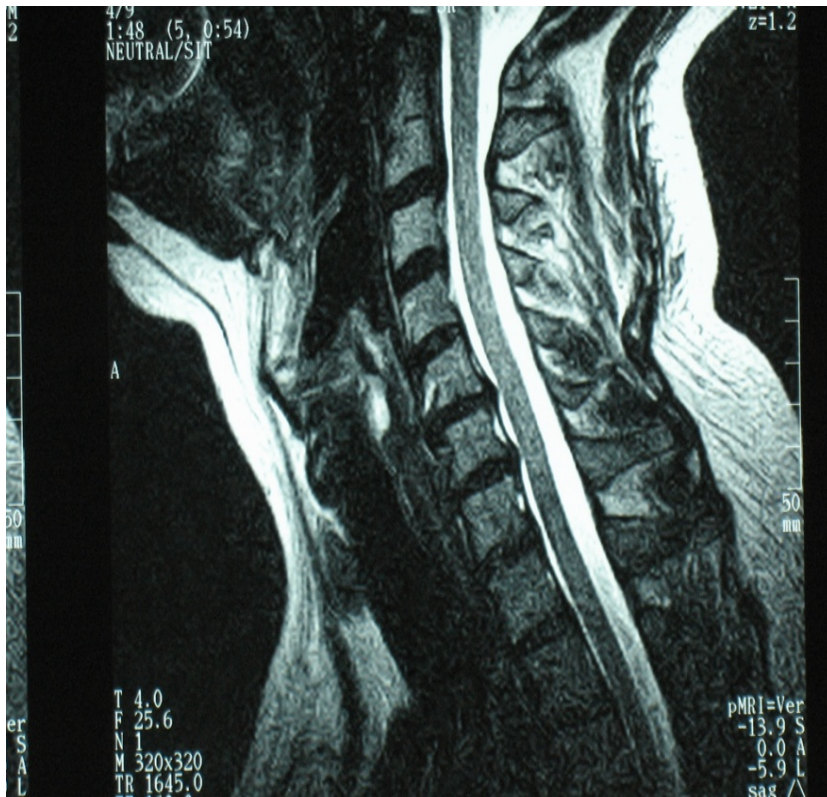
Cervical spine MRI, sagittal view. Note possible extruded disc material at C6-C7.
